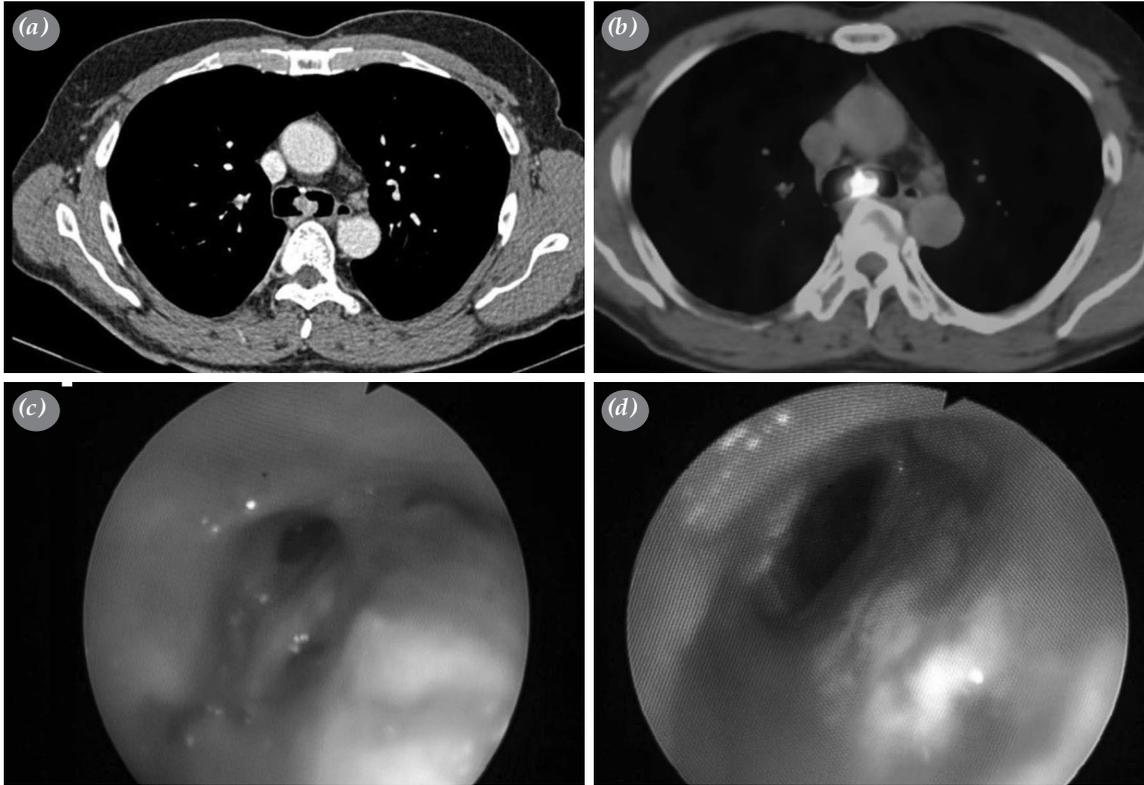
The patient who underwent carina resection due to a squamous cell lung carcinoma; (a and b) Image of tumor on thoracic computed tomography mediastinal window and 18F-fluorodeoxyglucose (18F-FDG) positron emission tomography/computed tomography image, (c) postoperative first-month bronchoscopy, stricture in the right main bronchus is seen. (d) After dilatation view of the right main bronchus.
